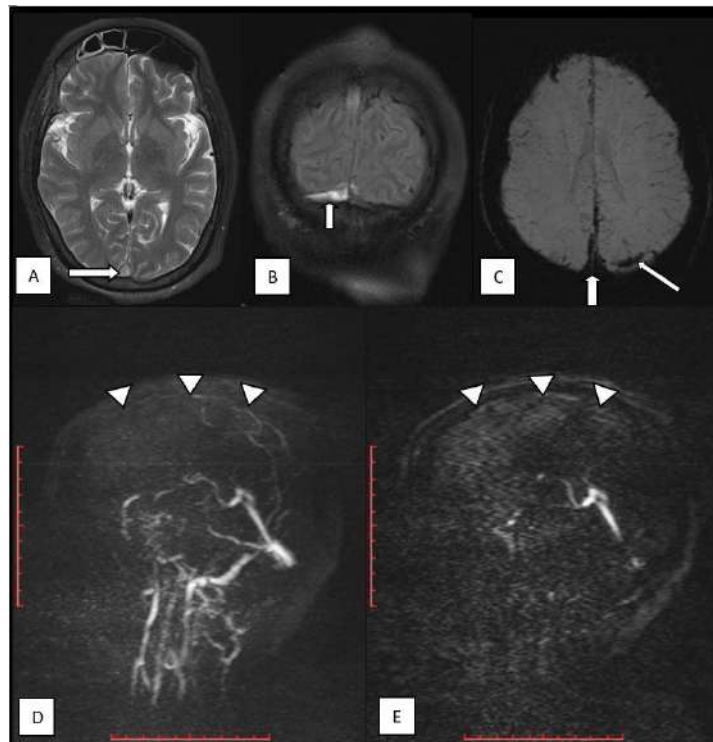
Non enhanced MRI images in a case of 32 year old female presenting with headache (A) T2 TSE axial image depicting the loss of normal flow voids with hyperintense signal involving the superior sagittal sinus (white arrow). (B) FLAIR coronal image depicting the loss of normal flow voids with hyperintense signal intensity involving the right transverse sinus (white arrow). (C) Axial SWI image showing the gradient blooming in the superior sagittal sinus (Broad arrow) and adjacent left cortical bridging vein (Thin arrow) suggestive of venous thrombosis. (D & E) MIP and 2D TOF MRV images depicting absence of flow signal (white arrow heads) involving the entire superior sagittal sinus confirming complete superior sagittal sinus thrombosis.
